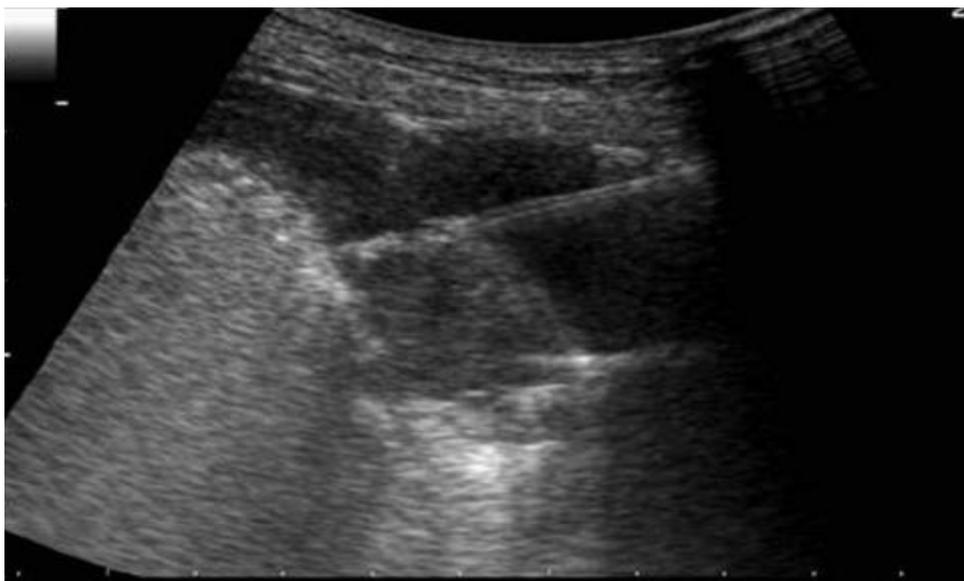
Image of an ultrasound guided lung tumor biopsy. The needle passes over the pleural effusion penetrating the tumor.
